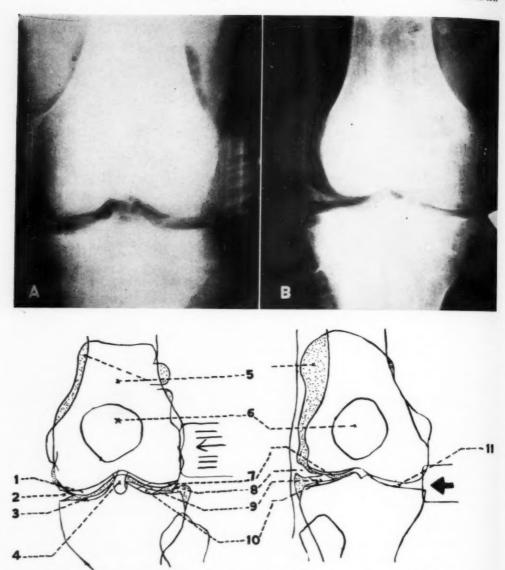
A and B. Radiographic anatomy of the knee joint. A. View obtained by spreading the medial joint space. B. View obtained by spreading the lateral joint space.
